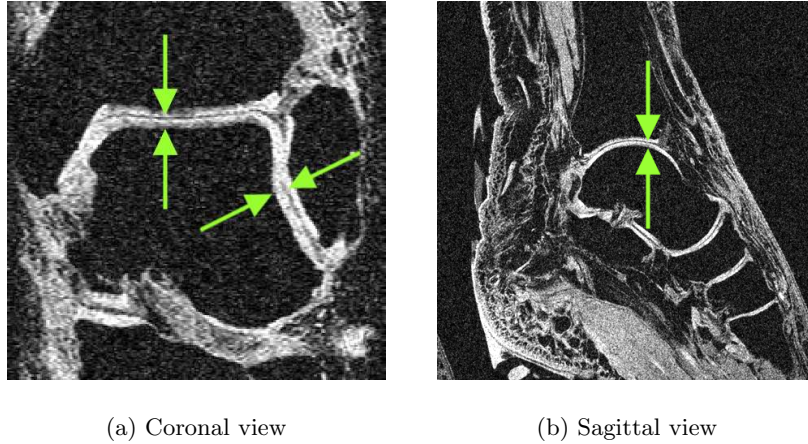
Two sample slices of a 3-D MR image of human ankle
